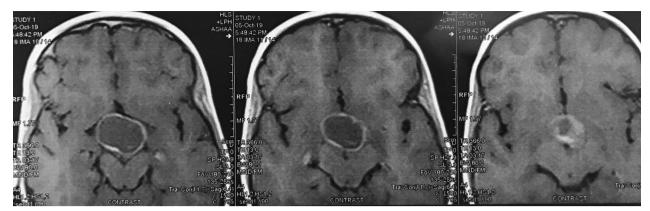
pre-operative MRI of patient 3
